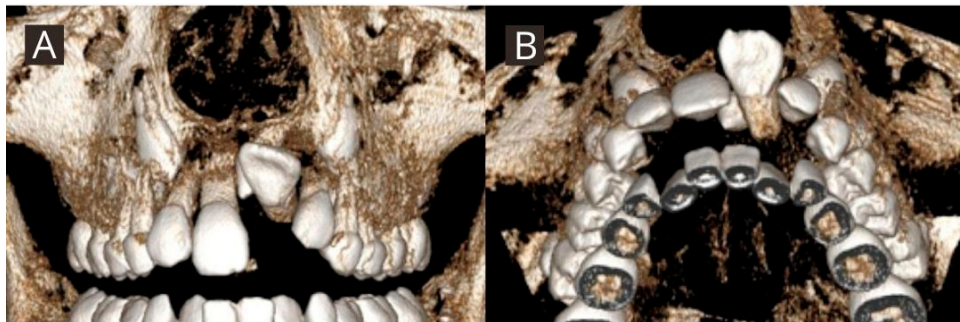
Three-dimensional representation of initial position of tooth 21 assessed in CBCT. A. Frontal view. B. Axial view.
